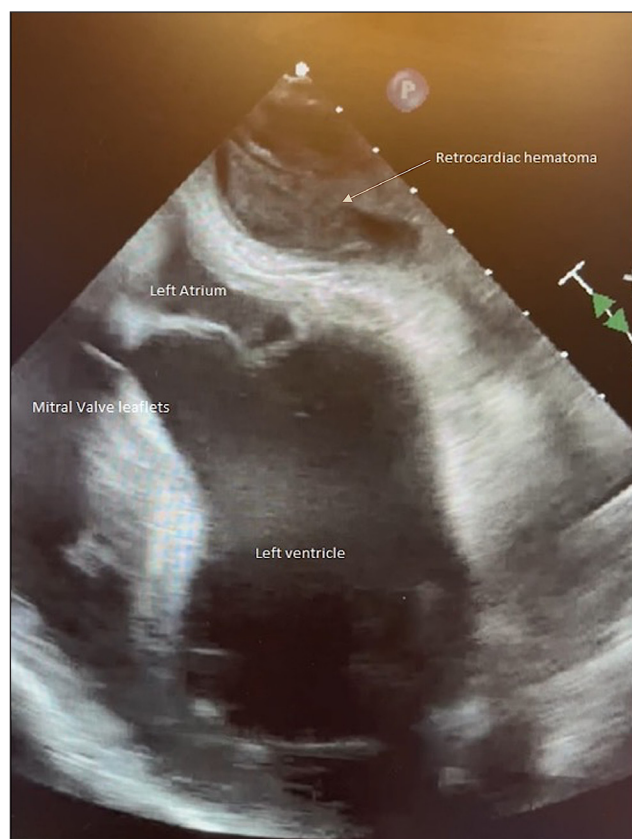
Intraoperative transesophageal echocardiographic image shows left atrial compression secondary to a retrocardiac hematoma caused by the Medtronic Pendent clip.
